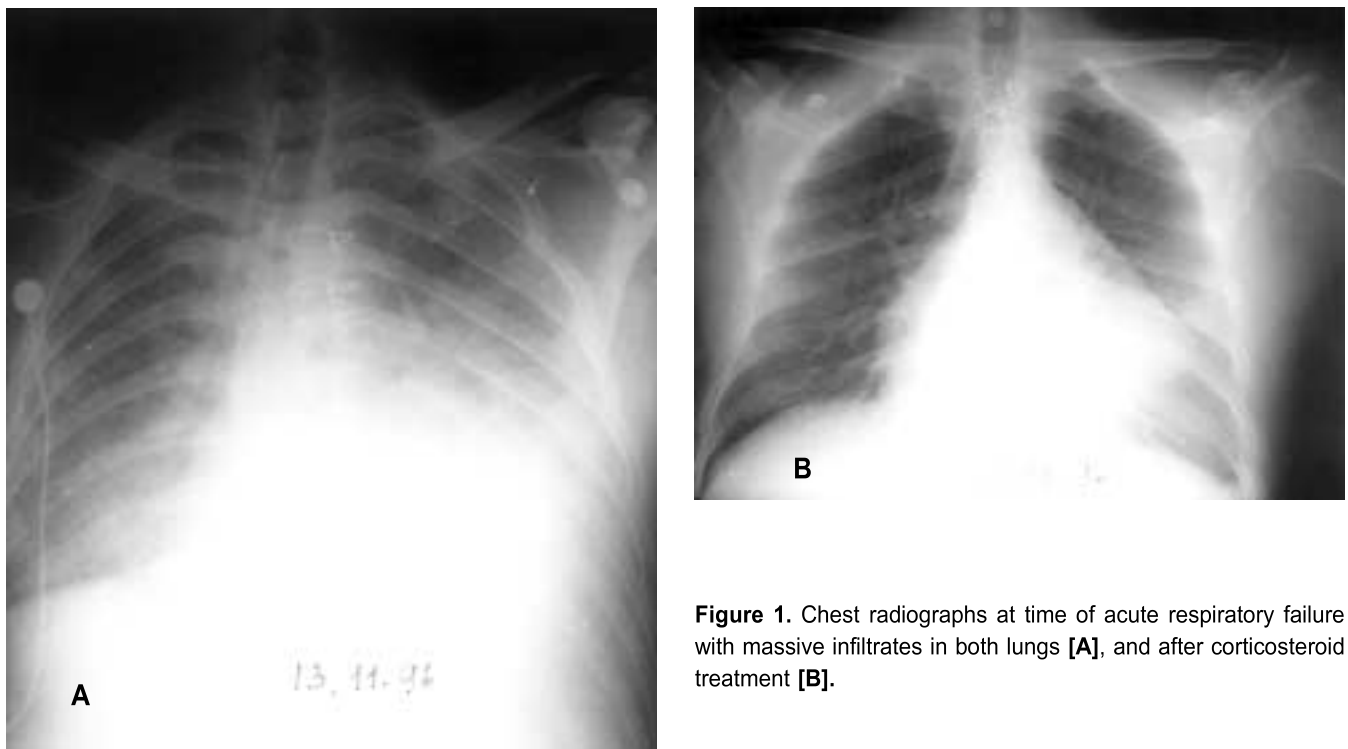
Chest radiographs at time of acute respiratory failure with massive infiltrates in both lungs [A], and after corticosteroid treatment [B].
